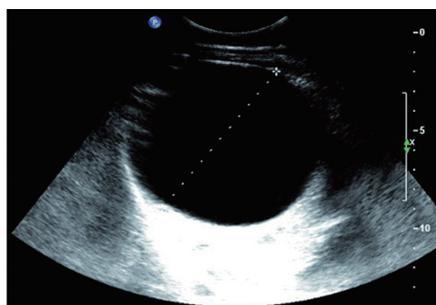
Abdominal ultrasound of a solitary simple liver cyst showing a well-defined anechoic unilocular fluid-filled lesion with posterior acoustic enhancement.
